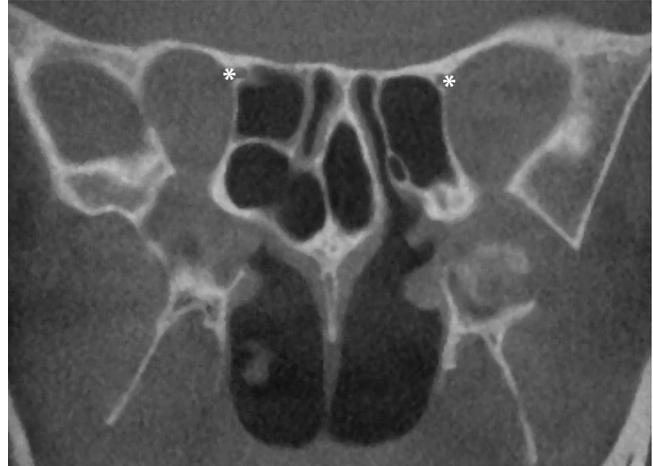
The posterior ethmoidal artery usually crosses within the ethmoidal roof, in front of the most superior aspect of the anterior wall of the sphenoid sinus. In 25-50%, the corticated sulcus of this artery (*) is identifiable on the coronal CT examination.
